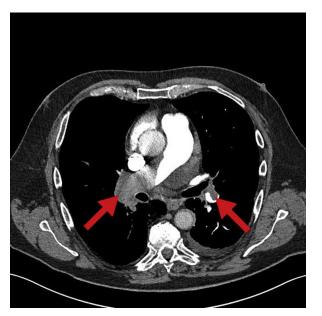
Chest computed tomography with PE protocol revealed a nearly occlusive PE in the right pulmonary artery and a nonocclusive PE in the left pulmonary artery (*arrows*).
